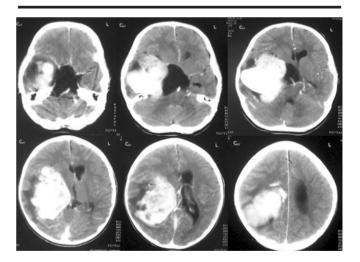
The preoperative CT scan of the patient showing a right intraventricular well-circumscribed lesion, perifocal edema and midline shift. There is a dense contrast enhancement and no dural based attachment.
